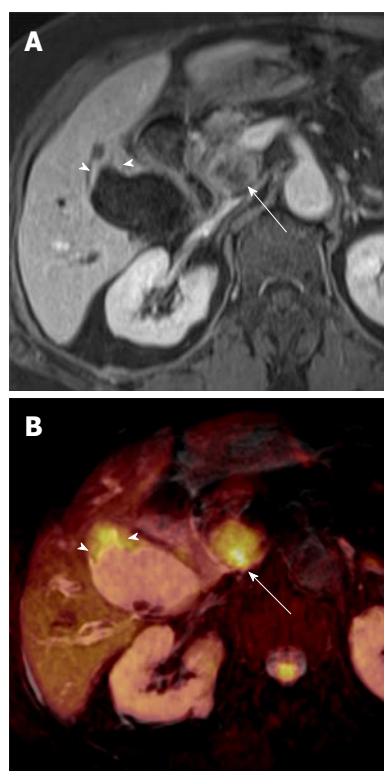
Gallbladder carcinoma (focal wall-thickening type) in a 77-year-old woman. A: Axial contrast-enhanced, fat-saturated, T1-weighted image shows focal wall thickening (arrowheads) in the gallbladder with a metastatic lymph node in the portocaval space (arrow); B: Fusion image of T2-weighted image and DWI at $b = 800 \text{ s/mm}^2$ shows focal, asymmetric high signal intensity in the fundal portion of the gallbladder (arrowheads) with a hyperintense metastatic lymph node in the portocaval space (arrow). DWI: Diffusion-weighted magnetic resonance imaging.
